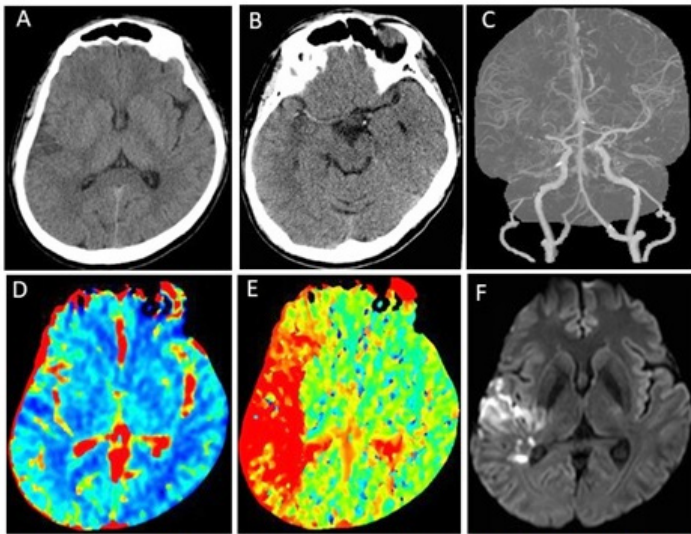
Non-contrast CT showed an area of hypodensity in the right insular cortex (A) and a hyperdense right MCA (B). CT angiogram revealed right M1 occlusion with excellent collaterals (C). CT perfusion demonstrated a small infarct core in the right posterior insular cortex (D) and a large area of the Time to Peak (TTP) prolongation, indicative of ischemic penumbra. A MRI brain scan confirmed acute infarction in the R MCA distribution (F).
